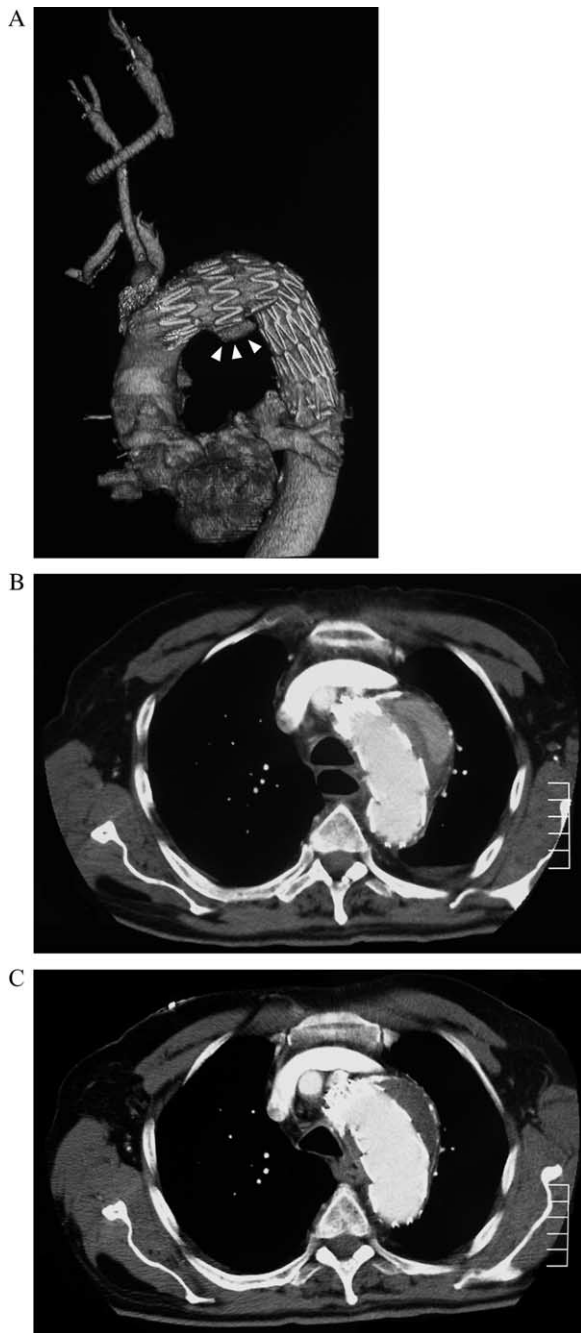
(A) Postoperative Angio-CT scan showing type I endoleak (arrows) after deployment of graft (Zenith Cook TX1) for aneurysm of zone '1'. Note over-stenting of the origin of the left common carotid artery that was grafted to right carotid artery with ringed ePTFE bypass. (B) Axial scan view of the endoleak. (C) Axial CT scan taken at the same level 6 months later showing no endoleaks, expansion of the stent graft with initial shrinkage of aneurismal sac.
